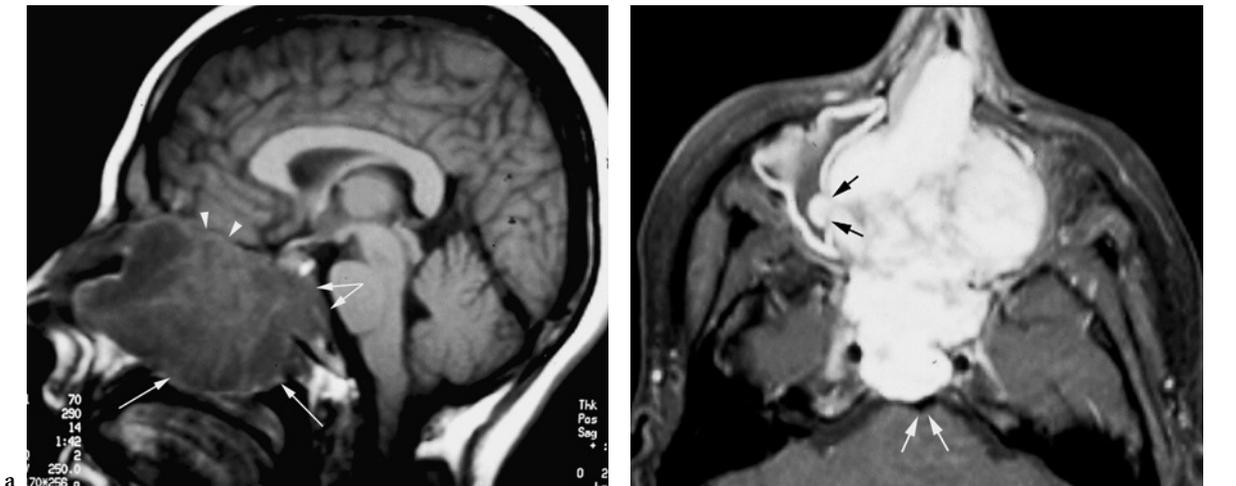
a,b. Chordoma. a Unenhanced T1-weighted sequence in the sagittal plane. A large extradural chordoma with invasion of the sphenoid sinus and ethmoid is shown. Replacement of bone marrow signal within the sphenoid bone (*double arrows*) with erosion of the posterior bony rim is detected. Intranasal extent reaches the planum sphenoidale from below (*arrowheads*). The mass projects into the nasopharynx (*white arrow*). b The chordoma shows relevant and heterogeneous enhancement. Extradural intracranial extent with basilar artery displacement (*white arrows*). Initial extent through the medial maxillary wall is present
